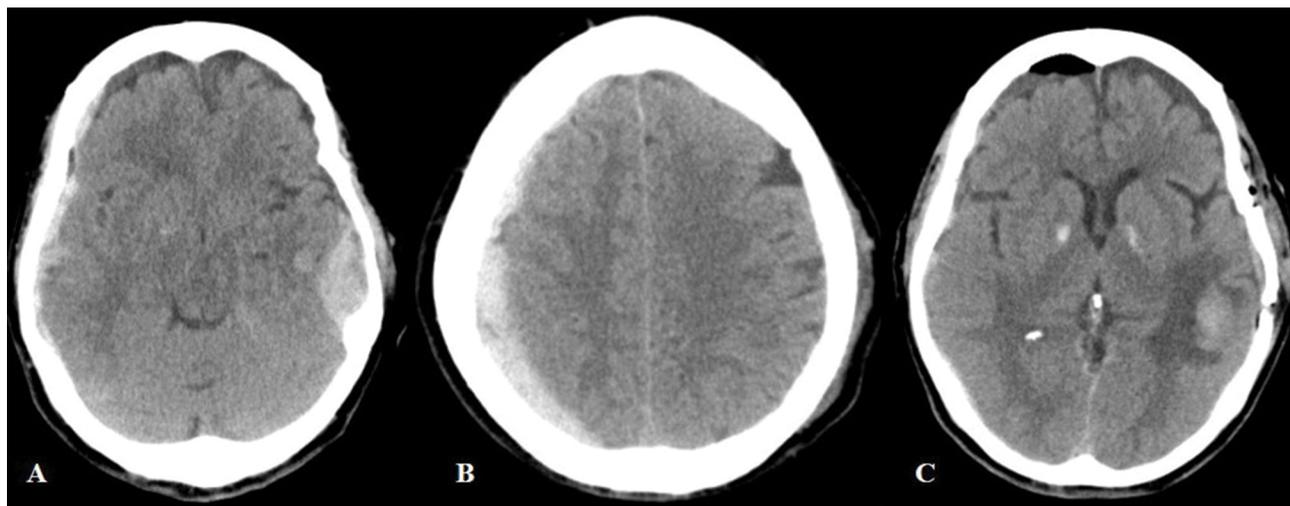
CT of an 82-year-old woman who fell down the stairs. A) Presence of an epidural hematoma in the left temporal region and a subdural hematoma in the right temporoparietal region; B) The location and size of the subdural hematoma were visualized; C) Post-operative CT shows the evacuation of the hematomas and the present brain contusion in the left temporal region.
